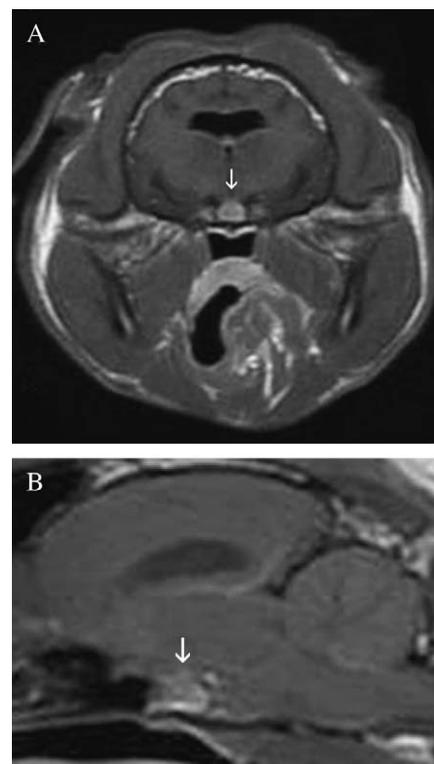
Transverse (A) and sagittal (B) T1-weighted magnetic resonance images of the brain following intravenous injection of gadodiamide contrast. A 5 mm diameter, contrast-enhancing mass (arrow) is present in the area of the pituitary
